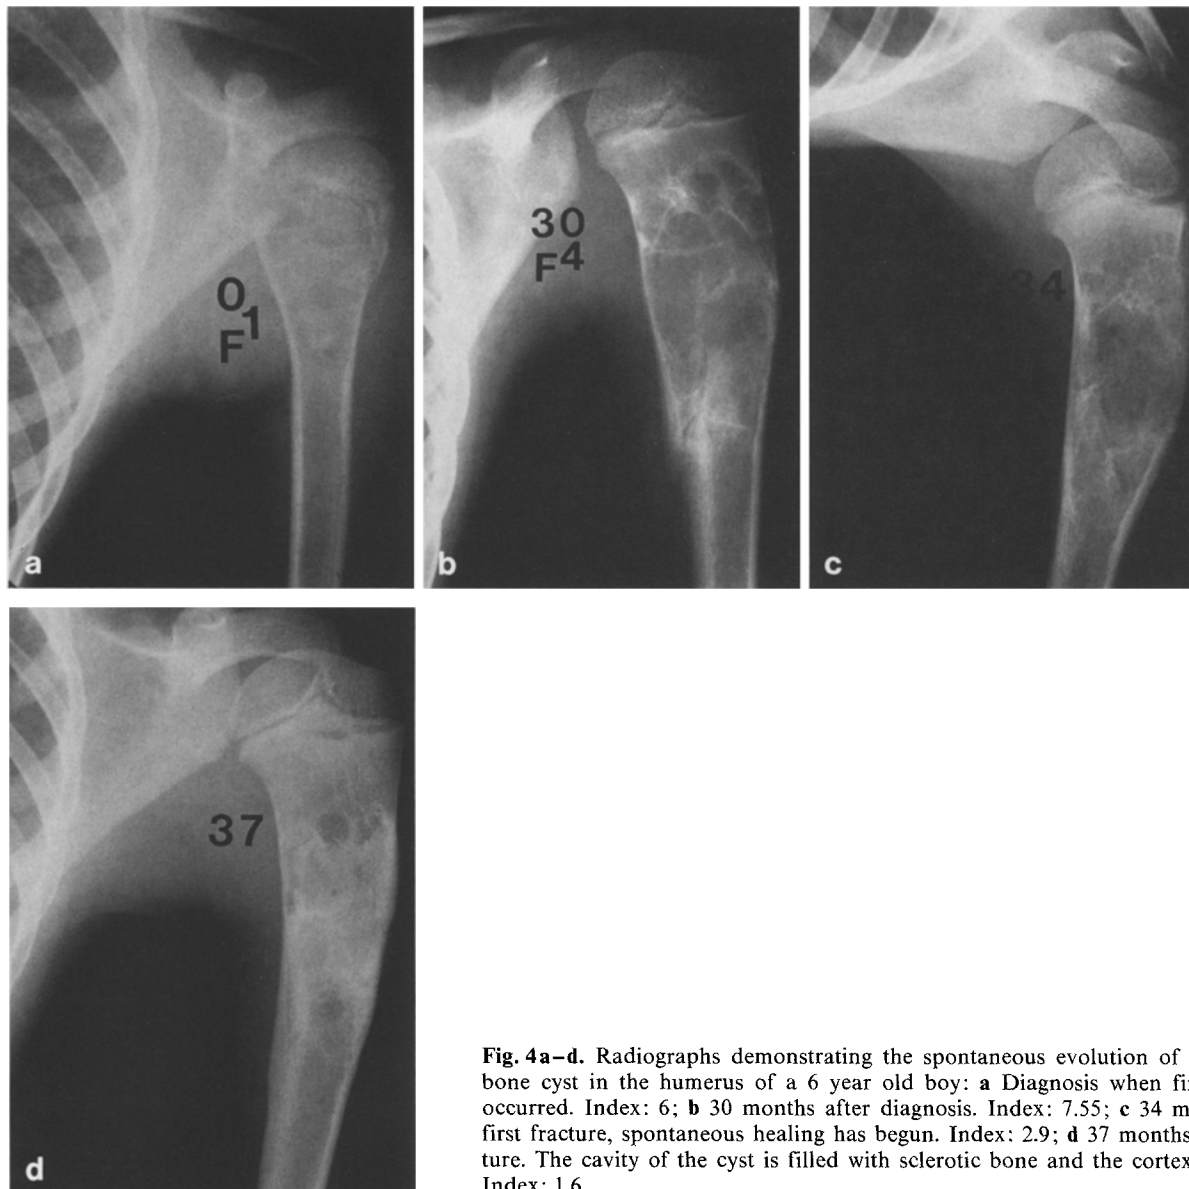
Radiographs demonstrating the spontaneous evolution of unicameral bone cyst in the humerus of a 6 year old boy: a Diagnosis when first fracture occurred. Index: 6; b 30 months after diagnosis. Index: 7.55; c 34 months after first fracture, spontaneous healing has begun. Index: 2.9; d 37 months after fracture. The cavity of the cyst is filled with sclerotic bone and the cortex is thicker. Index: 1.6
